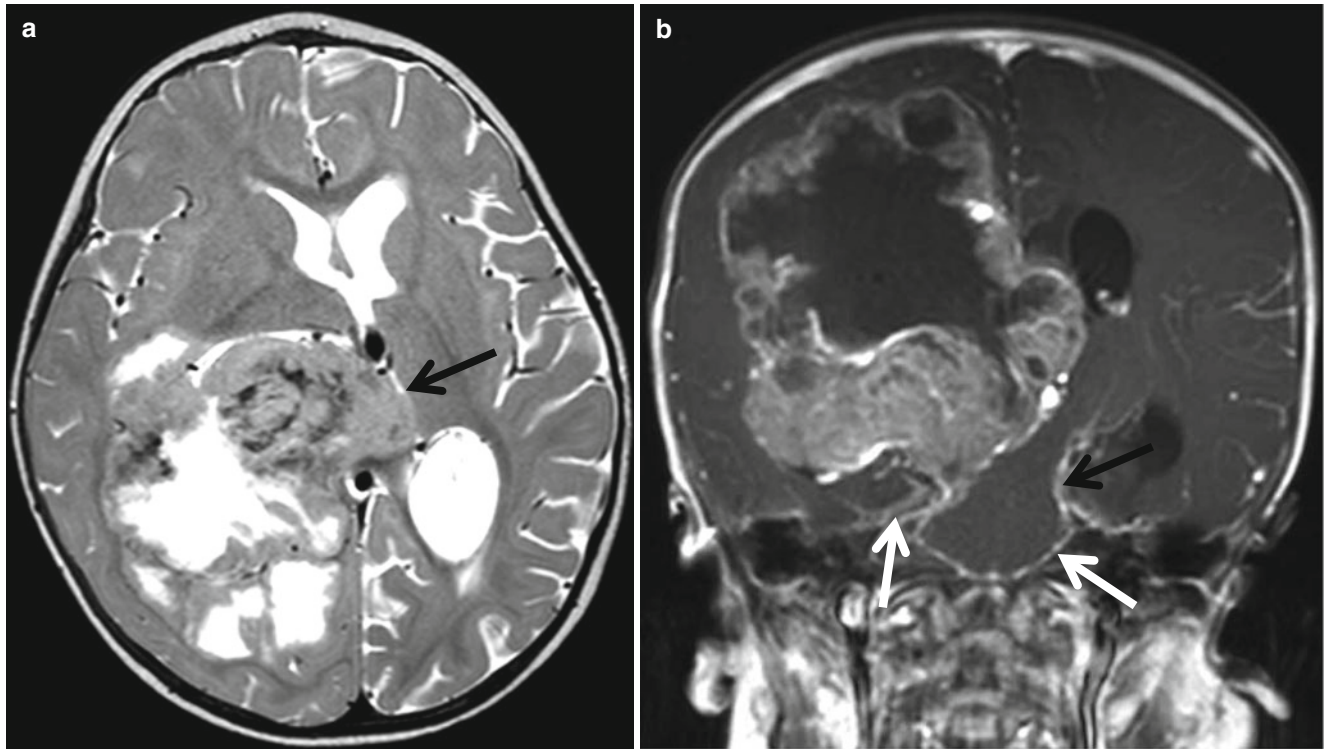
Primitive neuroectodermal tumor (PNET) in a 1-year-old boy. (a) T2-weighted image shows large mass (*arrow*) containing necrosis and calcification in the right occipital lobe and thalamus. The solid portions are isointense to gray matter. (b) Postcontrast coronal
